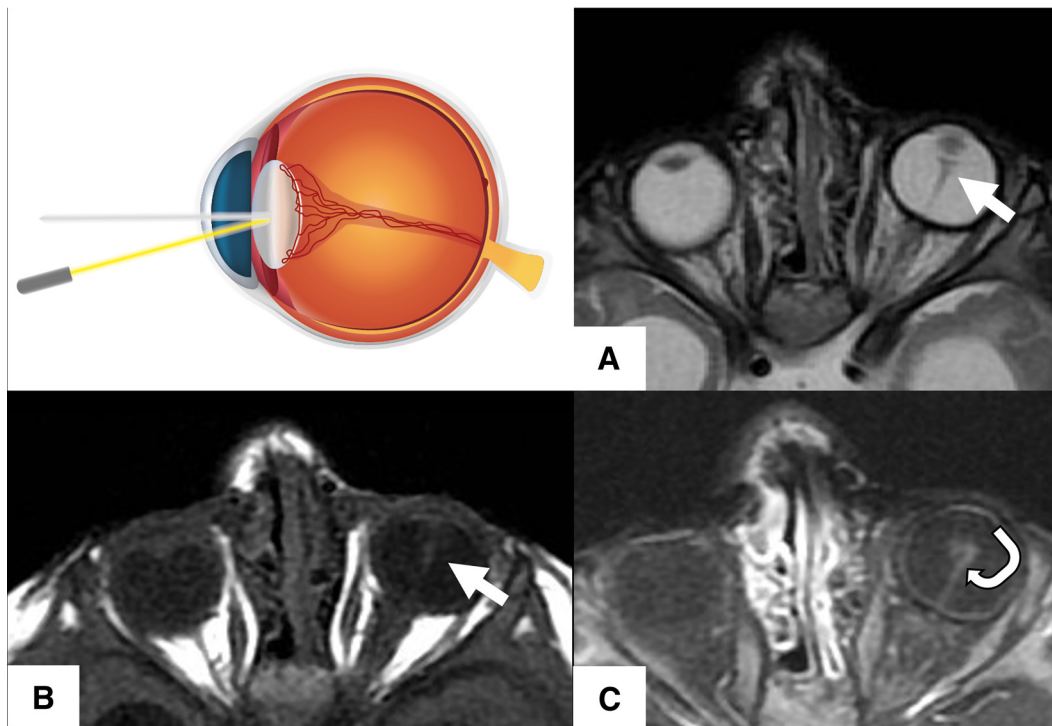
Persistent fetal vasculature of the left eye. Orbital MR imaging axial sequences, including T2-weighted (A), T1-weighted (B), and postcontrast T1-weighted (C), show left microphthalmia with the presence of retrolental fibrous tissue that extends posteriorly, which is hypointense on T2 and iso-intense on T1-weighted images (*arrows*). The fibrous tissue enhances following intravenous contrast administration (*curved arrow*).
